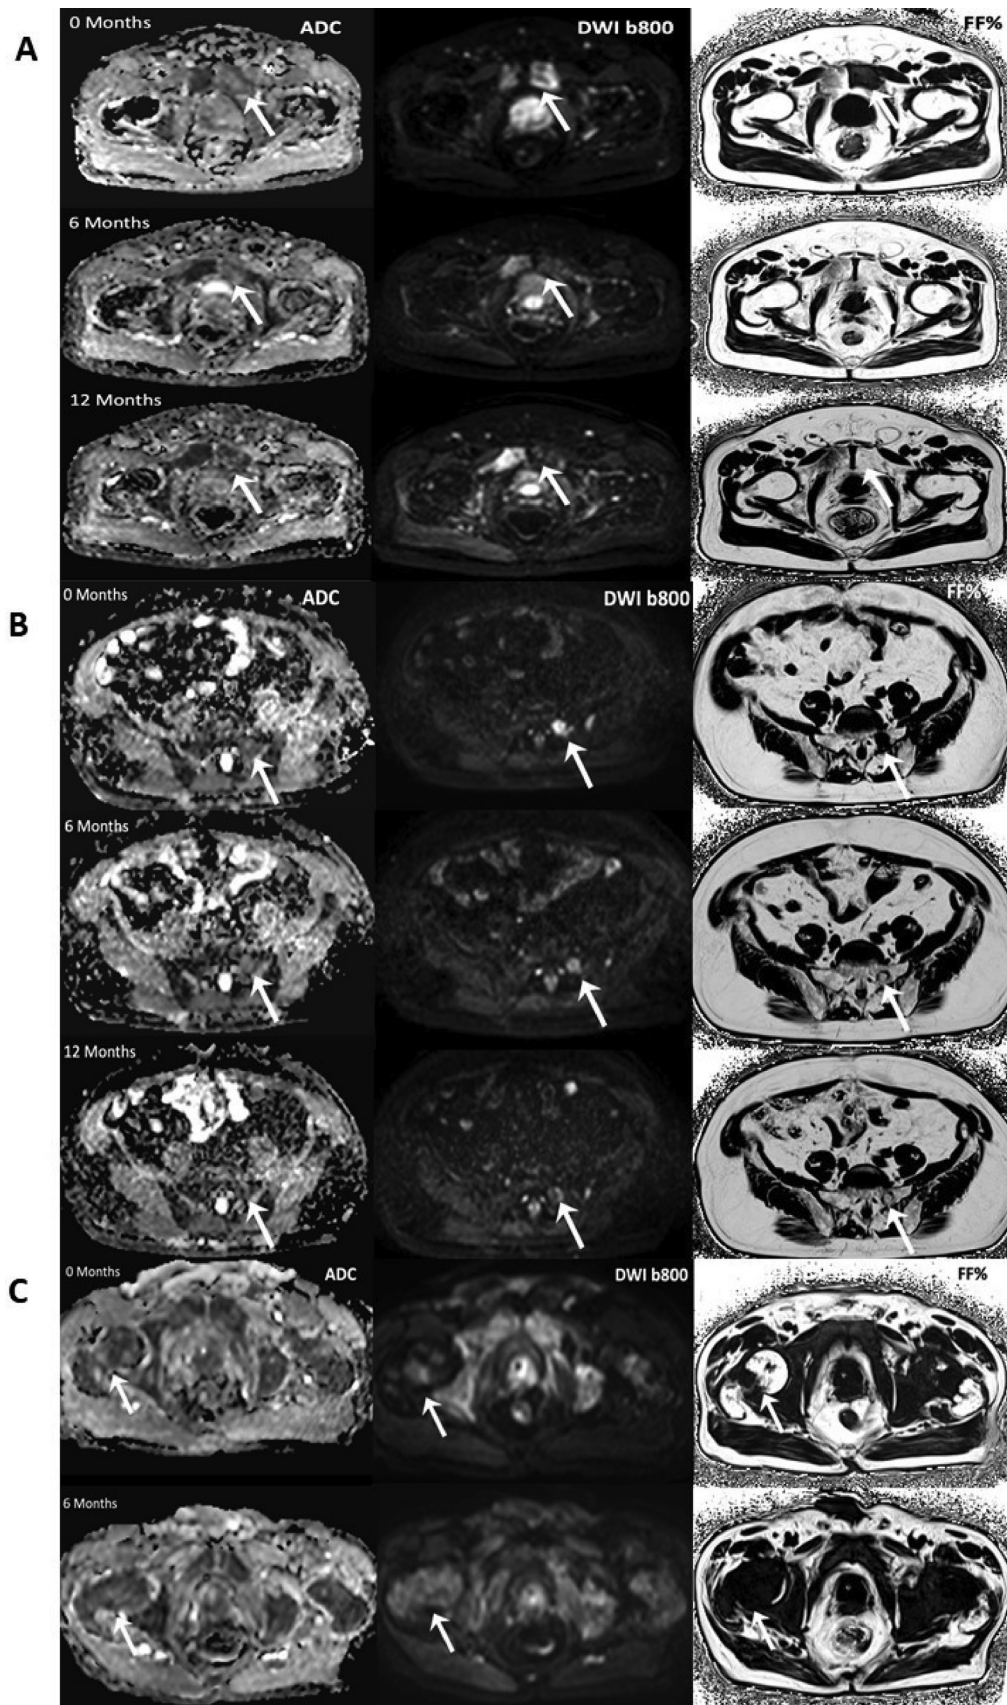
(A) Complete response of a metastatic lesion on the left pubic bone. The image shows a left pubic bone lesion before and 6 and 12 mo after treatment. There is complete response of the metastatic lesion, with normalization of the signal intensity on the high b-value sequence at 6- and 12-mo follow-up, fat repopulation of the bone marrow (fat fraction [FF%] sequence), high apparent diffusion coefficient (ADC) values (>1400) at 6-mo follow-up, and a reduction to normal bone ADC values at 12-mo follow-up and complete disappearance on the T1-weighted sequence. (B) Partial response of a metastatic lesion on the left sacral ala. This patient had a left sacral ala lesion (white arrow) before treatment, with a slight reduction in signal on the high b-value sequence at 6- and 12-mo follow-up without changes in ADC values and the appearance of intratumoral fat within the lesion. (C) Progression of a metastatic lesion on the right femur. This patient had a small lesion at the neck of the right femur (white arrow) that had increased in size at 6-mo follow-up, with ADC and FF% values indicating an active lesion. DWI = diffusion-weighted imaging.
